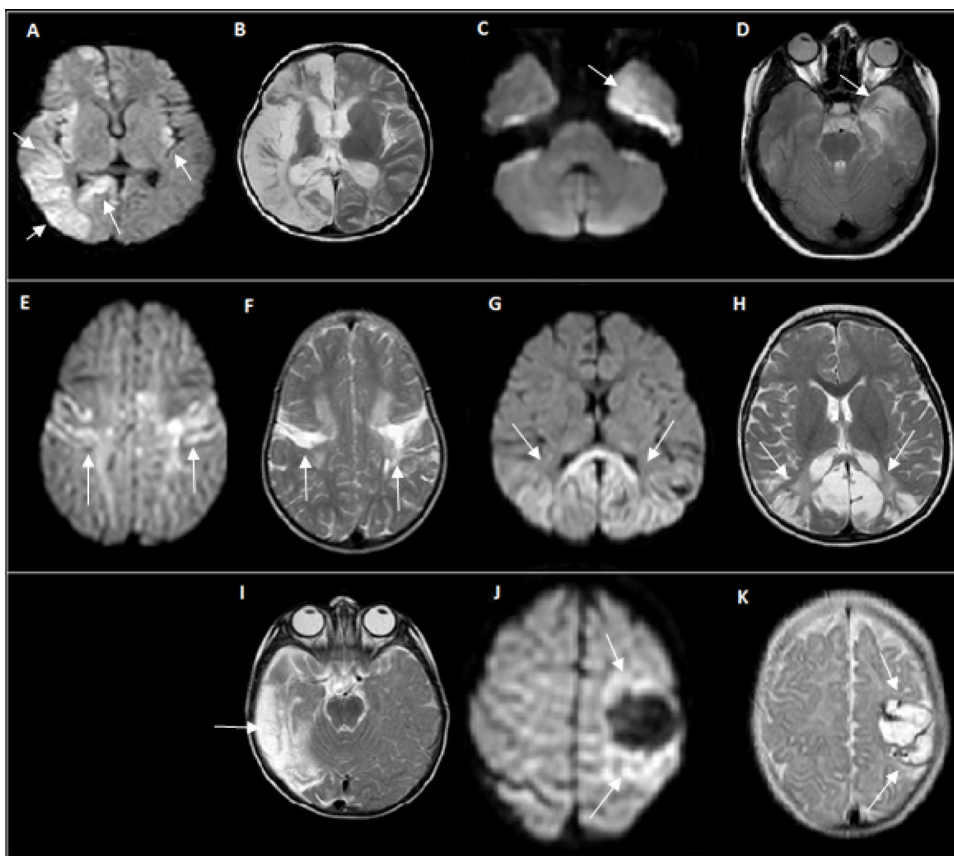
Cranial MRI of patients, diffusion weighted axial image at the acute stage (A, C, E, G, J), and T2-weighted axial image (B, D, F, H, I, K) at the chronic stage. Diffusion restriction in the acute phase resulted in encephalomalacic changes at the chronic stage in all patients (arrows). Patient-1 at 20 months old (A), and 34 months old (B), has diffuse right hemisphere involvement, mild involvement in left frontal, temporal and occipital lobes. Patient-2 at 22 months old (E), and 29 months old (F), has perirolandic involvement bilaterally more prominent in the left hemisphere. Initial MRI of patient-3 taken at 11 months old is not available, at 17 months old there is right temporo-occipital encephalomalacia. Patient-4 at 10 years old (C) and 11 years old (D), has left temporal lobe involvement. Patient-5 at 18 months old (G) and 23 months old (H), has corpus callosum splenium and bilateral occipital lobe involvement. Patient-6 at 4 months old (J) and 5 months old (K), has left perirolandic involvement, with some hemorrhagic component, extending to left temporo-occipital lobes.
